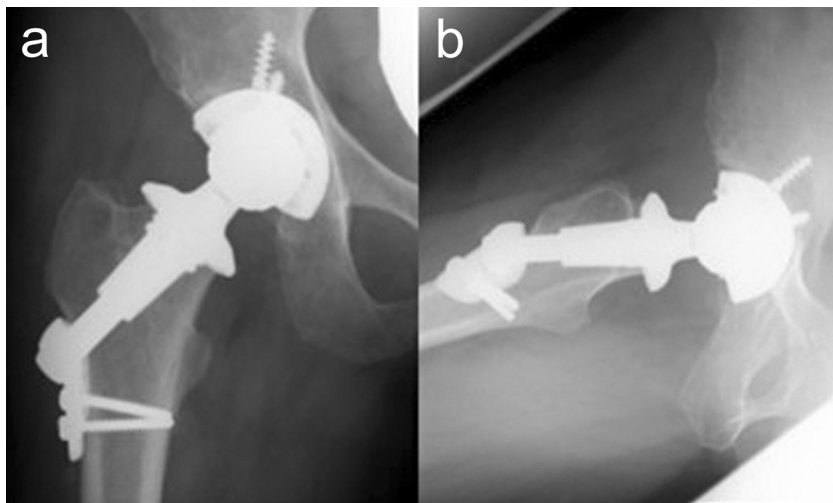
(a) Anteroposterior and (b) lateral radiographs at the time of total hip arthroplasty (THA) with the thrust plate hip prosthesis (TPP). The insertion angle of the thrust plate to the femoral axis was 130° on the postoperative anteroposterior radiograph.
